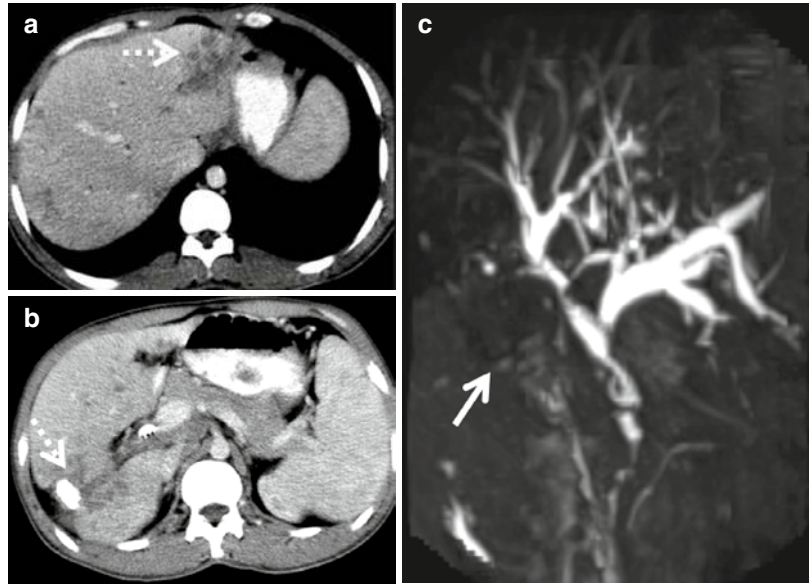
Recurrent pyogenic cholangitis. Contrast-enhanced CT (a) and T2-weighted axial MRI (b) through the upper abdomen show crowding and dilatation of intrahepatic biliary radicles typically involving the left lateral
